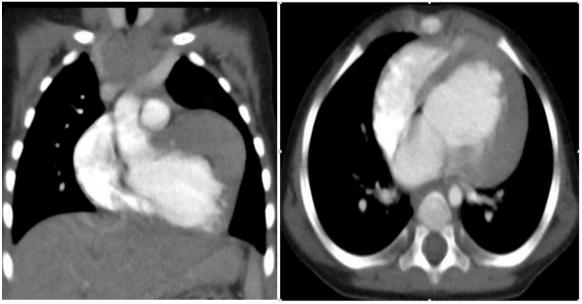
CT thorax – Coronal (A) and Axial (B)
